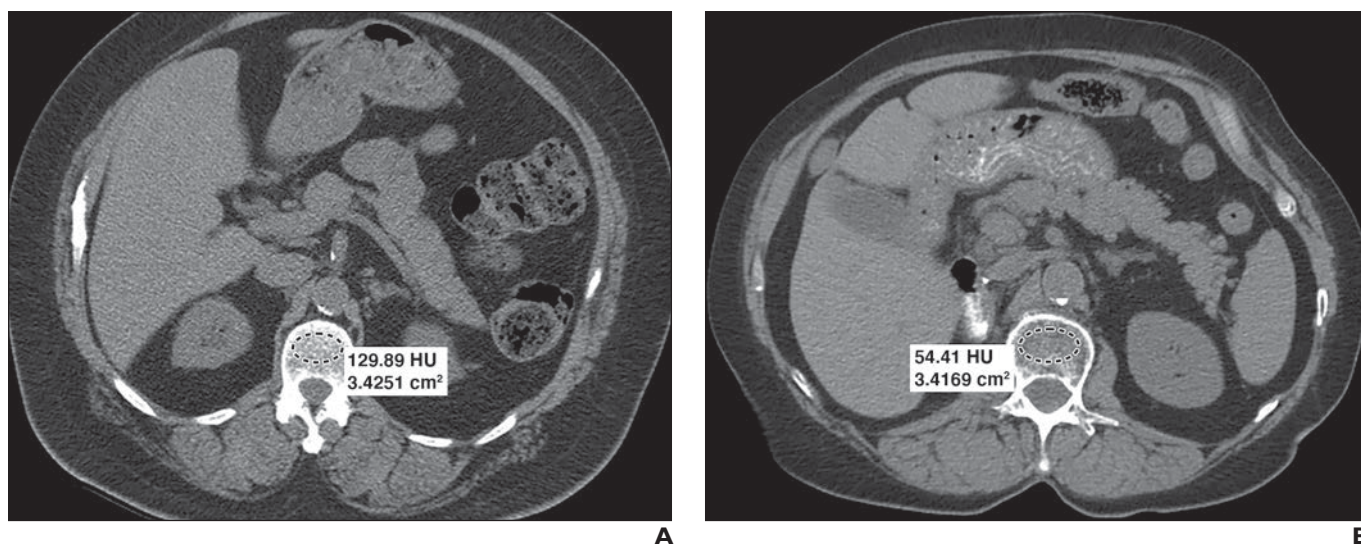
Images from opportunistic CT of bone. Dashed ovals denote ROIs.
